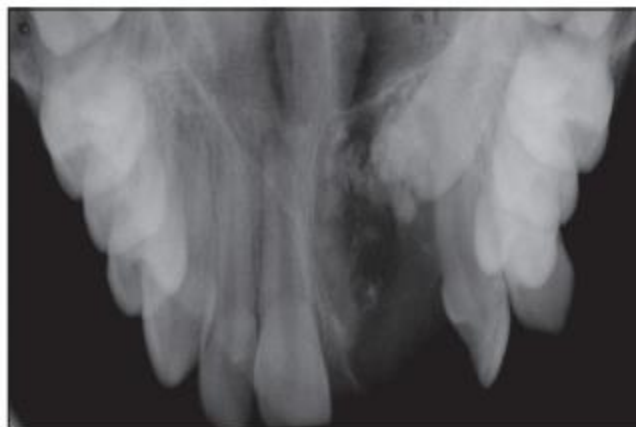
Maxillary occlusal radiograph showing well defined unilocular radiolucency with specks of radiopaque foci involving 21
